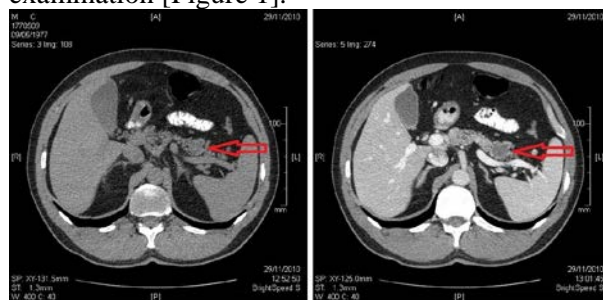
Left: Non-enhanced CT scan - hypodense focal mass of 20mm in diameter with clear delimitation, situated in the tail of the pancreas; Right: Contrast-enhanced CT, arterial phase – there is no visible contrast enhancement of the tumoral mass.
